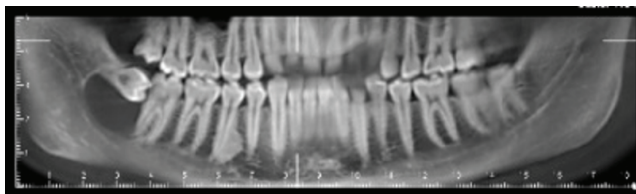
The image of cone-beam computed tomography for dentigerous cyst
